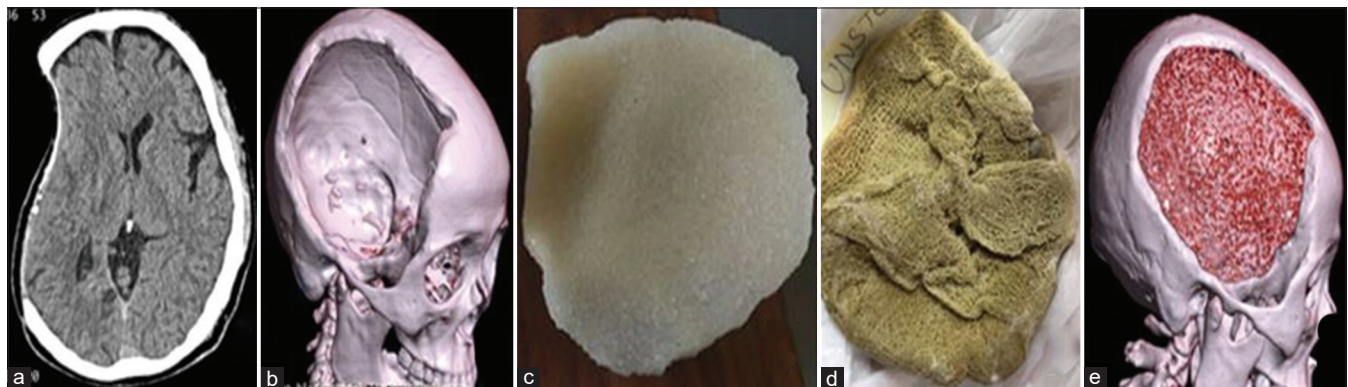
Preoperative axial 1-mm computed tomography data (a) being converted to three-dimensional image showing the cranial defect (b) with development of implant model (c). Infected autologous bone (d). Postoperative three-dimensional computed tomography with prosthesis placement (e)
